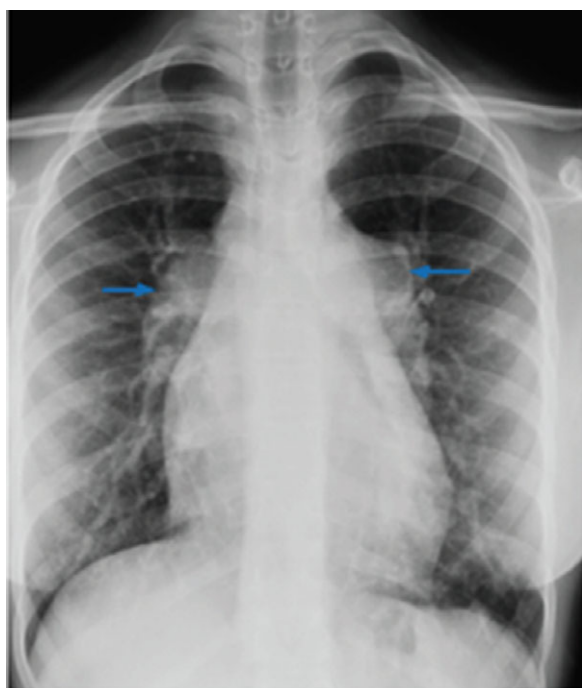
Chest X-ray with blue arrows demonstrating left-sided morphology of both pulmonary arteries.
